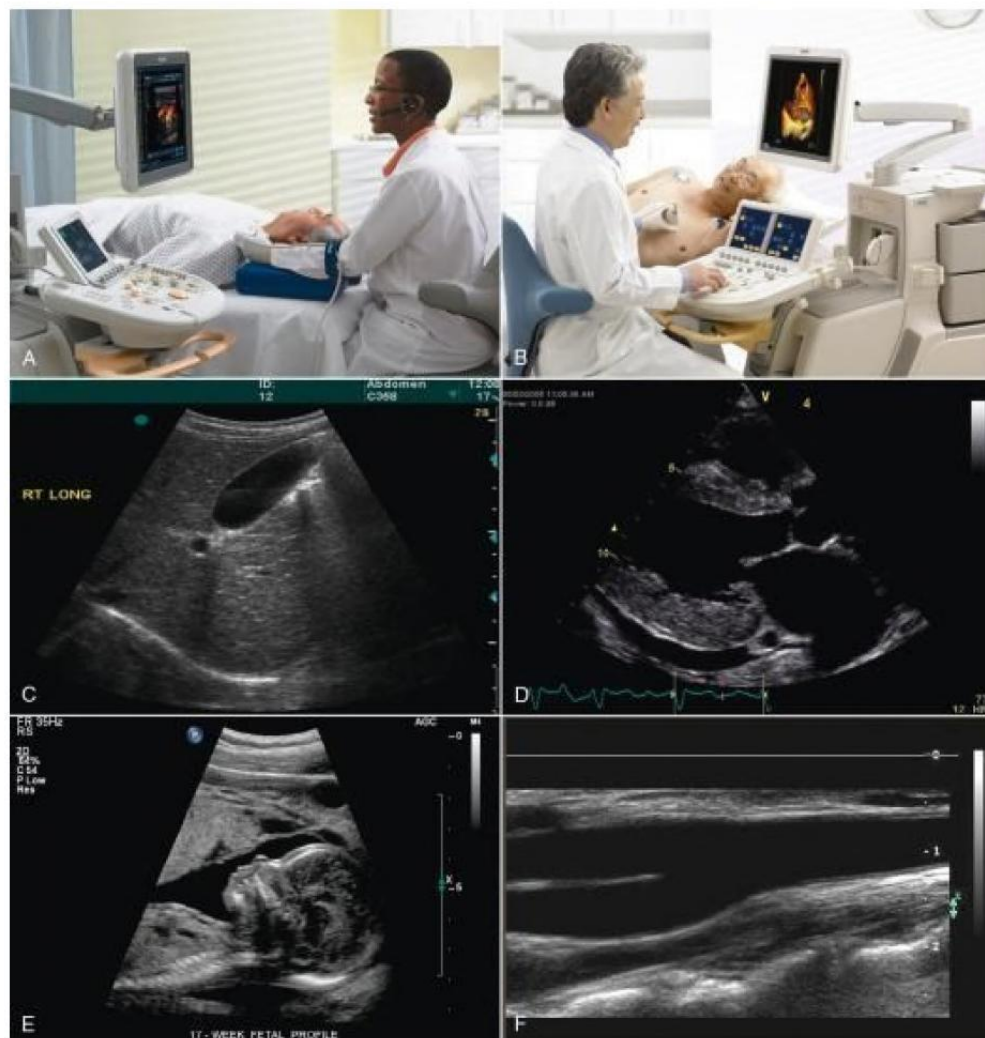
Ultrasound provides a window into the human body, allowing us to see what would otherwise be hidden from view (A–B). Images shown are as follows: C, abdominal; D, cardiac; E, obstetric; and F, vascular.
